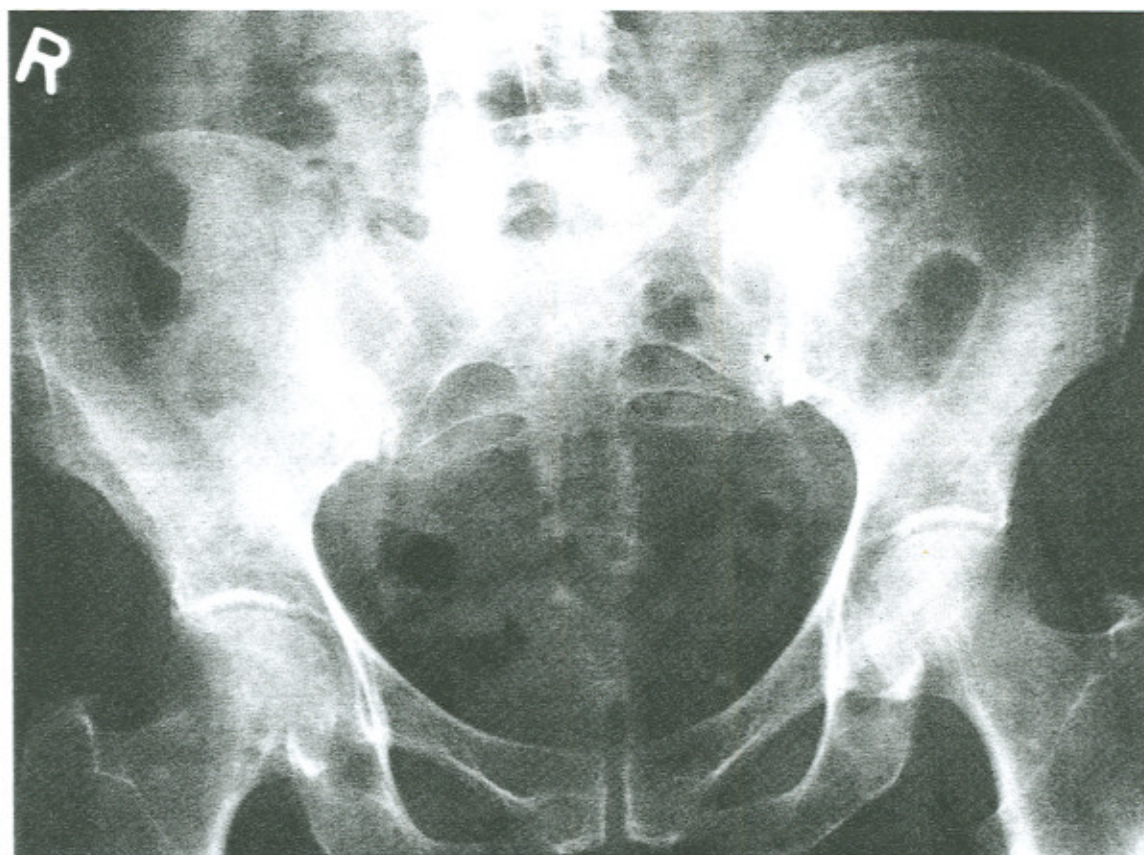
A pelvic radiograph shows a 7 × 8 cm area of mottled sclerosis with ill-defined margins within the left ilium.
